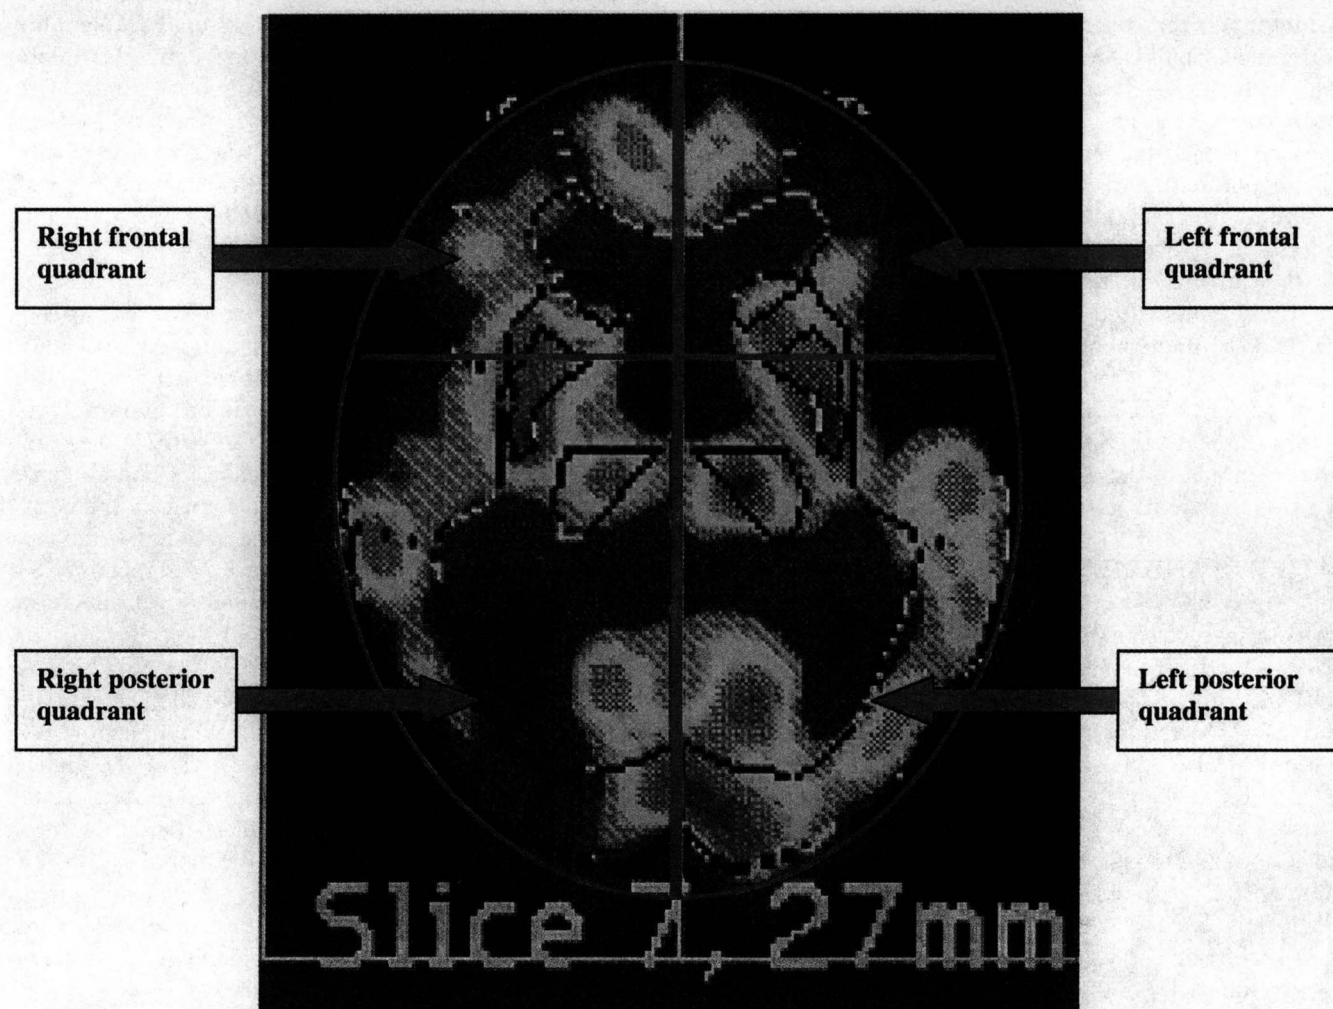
SPECT regions: the four quadrants. The brain regions identified by the superimposed templates are shown at level 27 mm above the orbitomeatal plane. In total, rCBF values from 13 subregions (see Tables 4 and 5, regions F1–F6, T1–T3, P1–P3, and OC1) were calculated from the nine SPECT image slices. For individual image analysis, the SPECT images were split into four quadrants, and the statistical methods described were applied. Regional CBF values from the basal ganglia (regions drawn on figure around thalami, caudate nuclei, and putamen) were not used in the regional analysis.
